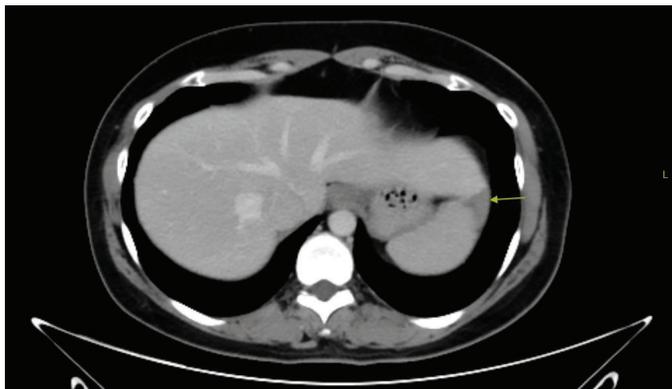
CT examination shows a hypodense lesion in the beaver tail liver.
